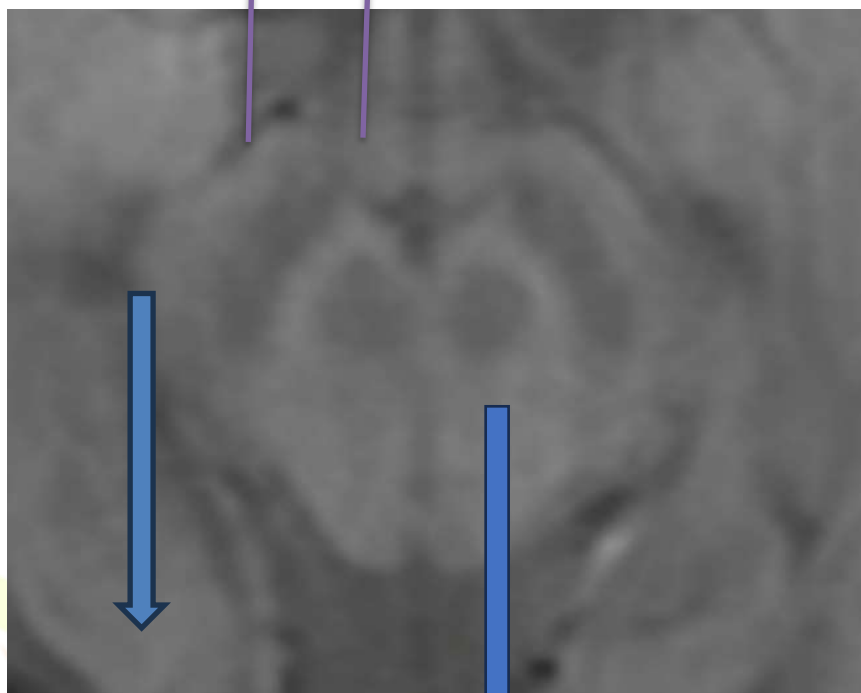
A 51 years old male patient presented with resting pill rolling tremors ,paucity of movements, gait disturbances MRI axial SWI image showing bilateral loss of swallow tail sign diagnosed as Idiopathic Parkinsons Disease.
